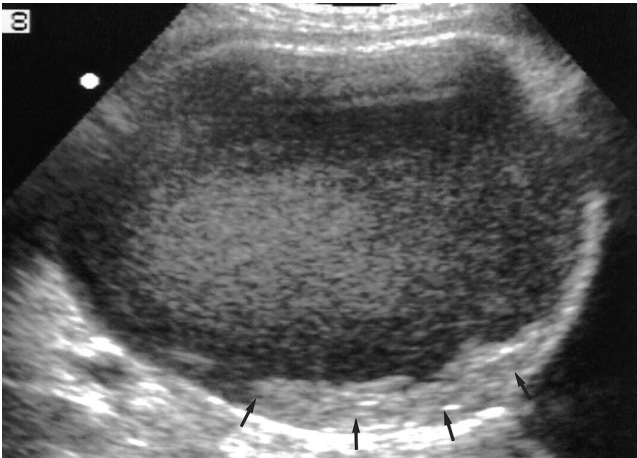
Endometrioma of the left ovary in a 22-year-old woman. Longitudinal transabdominal ultrasonogram shows diffuse fine internal echoes and solid component in posterior wall (arrows).
